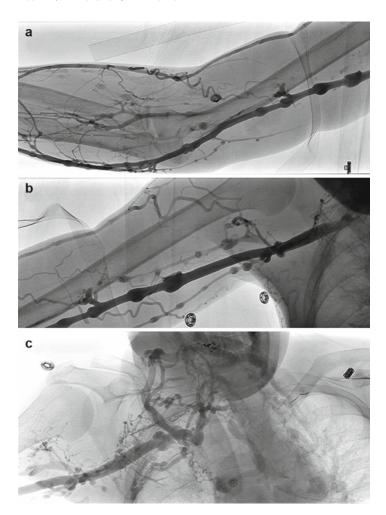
(a) Right upper extremity venogram of a 38-year-old man with a failed arteriovenous graft. The patient had an ultrasound that demonstrated a patent basilic vein. Venography is essential for workup of patients with failed access. Figures (a) and (b) would suggest that this patient is a candidate for basilic vein transposition; however Fig. (c) demonstrates central vein occlusion that could not be imaged by ultrasound
